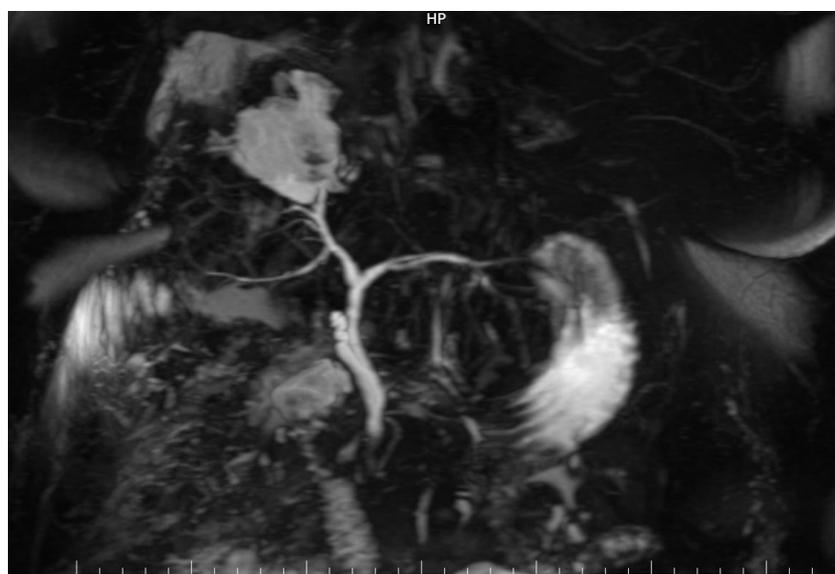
MRI showing cysto-biliary fistula between hydatid cyst residual cavity of segment VII of the Liver and posterior biliary duct
